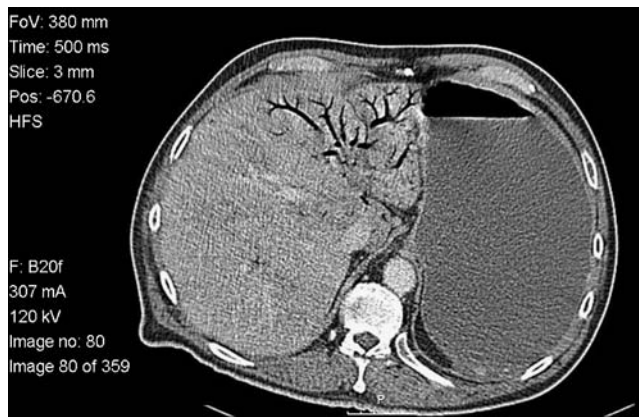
CT scan showing air throughout the portal venous system.
